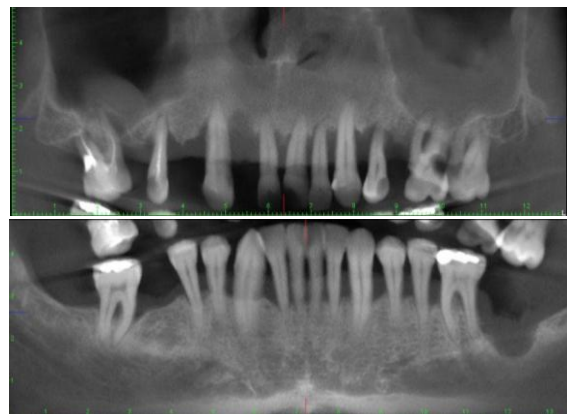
CBCT image showing severe periodontitis with important bone loss and enlargement of Schneiderian membrane.
